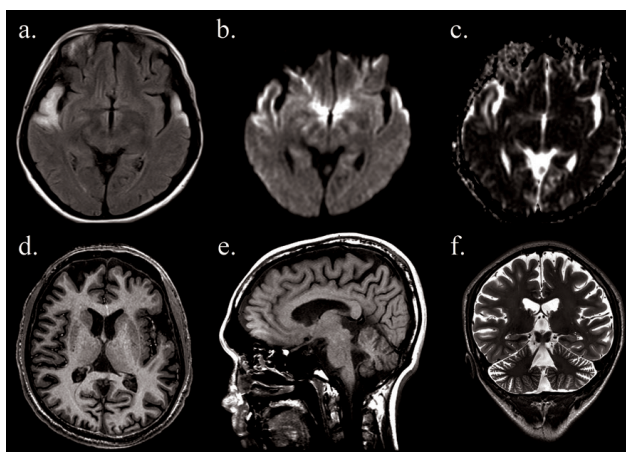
Brain MRI of the two patients with m.3243A>G mutations in this study.
